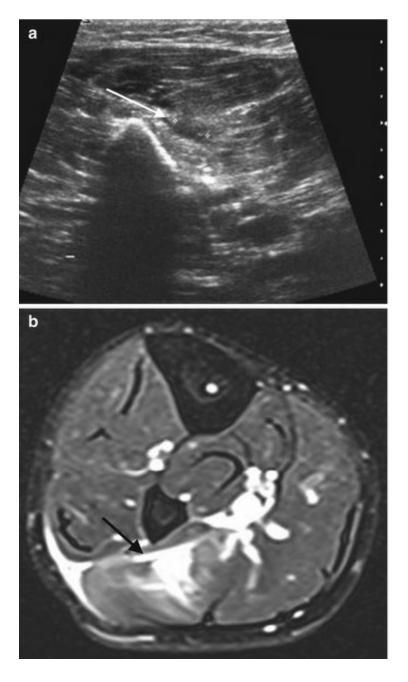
A 26-year-old man with moderate right calf pain. Transverse ultrasound image (a) shows a 5 mm hypoechoic area in the soleus muscle (*arrow*). (b) Axial fat-suppressed T2-weighted MRI confirms grade 2 soleus muscle injury (*arrow*)
